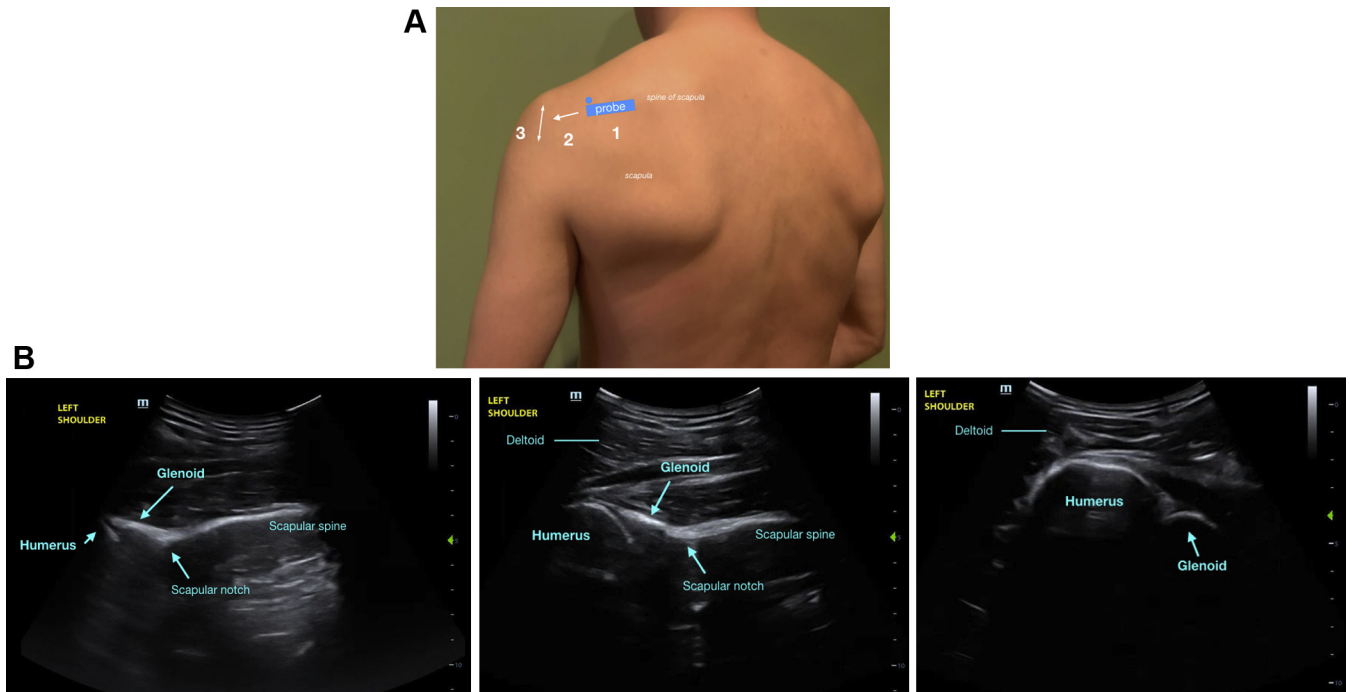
A, Proper probe placement on the patient and the 3-step sequence to examine the shoulder from the posterior approach. The blue dot above the probe corresponds to the probe indicator. B, The corresponding ultrasonographic images to the probe placement in A at the level of the scapular spine (1), the glenohumeral joint (2), and the humerus (3).
